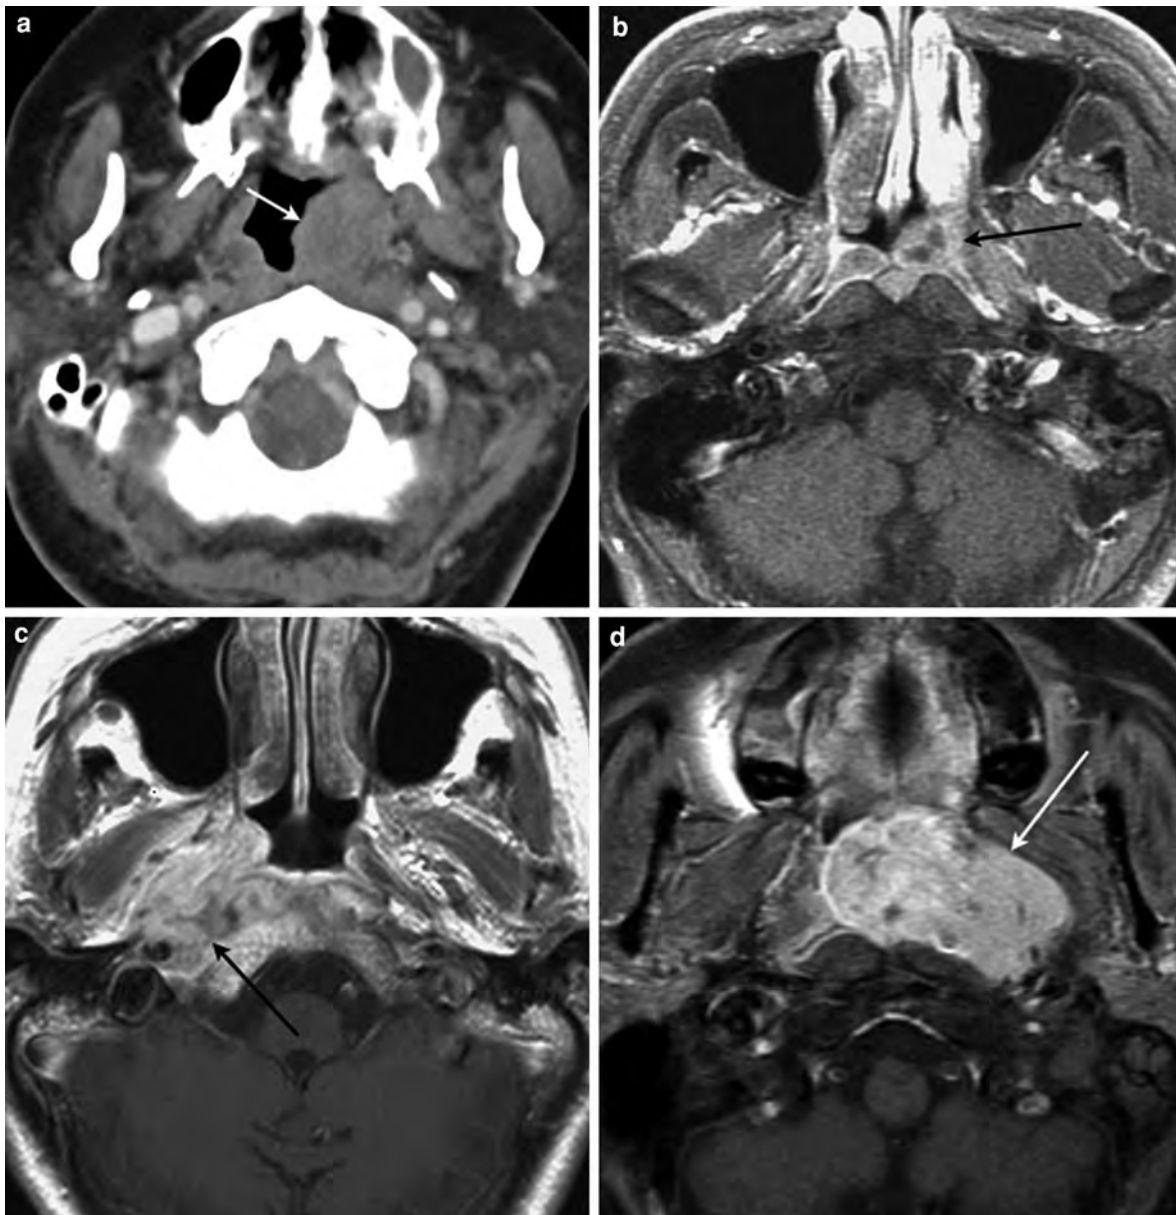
a Nasopharyngeal non-Hodgkin's lymphoma. Axial contrast-enhanced CT image shows a left nasopharyngeal tumour (*arrow*) with no significant invasion of the adjacent deep cervical spaces. b Nasopharyngeal mucosa-associated lymphoid tissue (MALT) lymphoma. Axial contrast-enhanced T1-weighted MR image shows a left nasopharyngeal tumour (*arrow*). The tumour is largely confined to the pharyngeal mucosal space. c Nasopharyngeal extramedullary
